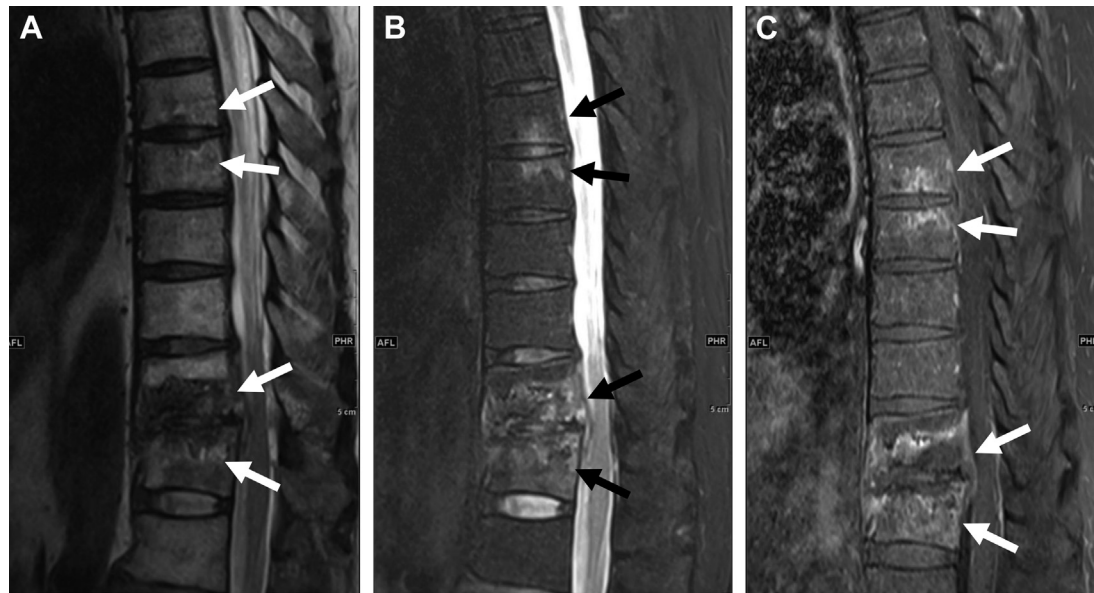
Early stage of tuberculous spondylitis. Sagittal T2-weighted (A) and fat-suppressed T2-weighted MR imaging (B) show high signal bone marrow edema in the T7, T8, T11, and T12 vertebral bodies (arrows), skipping the intervertebral disks and intervening normal segments. (C) The lesions show enhancement on sagittal T1-weighted postcontrast MR imaging.
